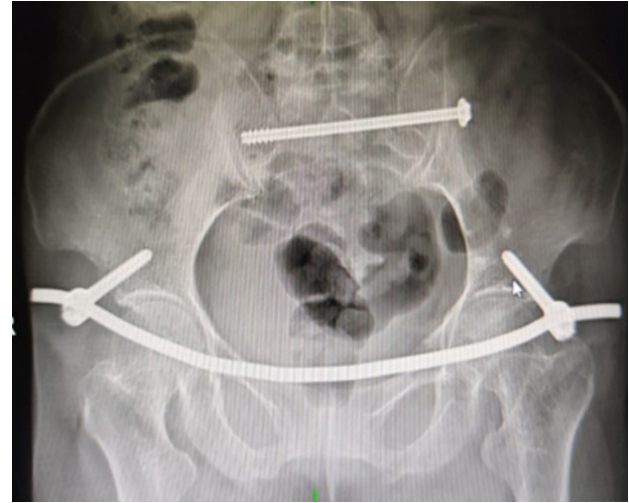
Postoperative pelvic anteroposterior X-ray.
